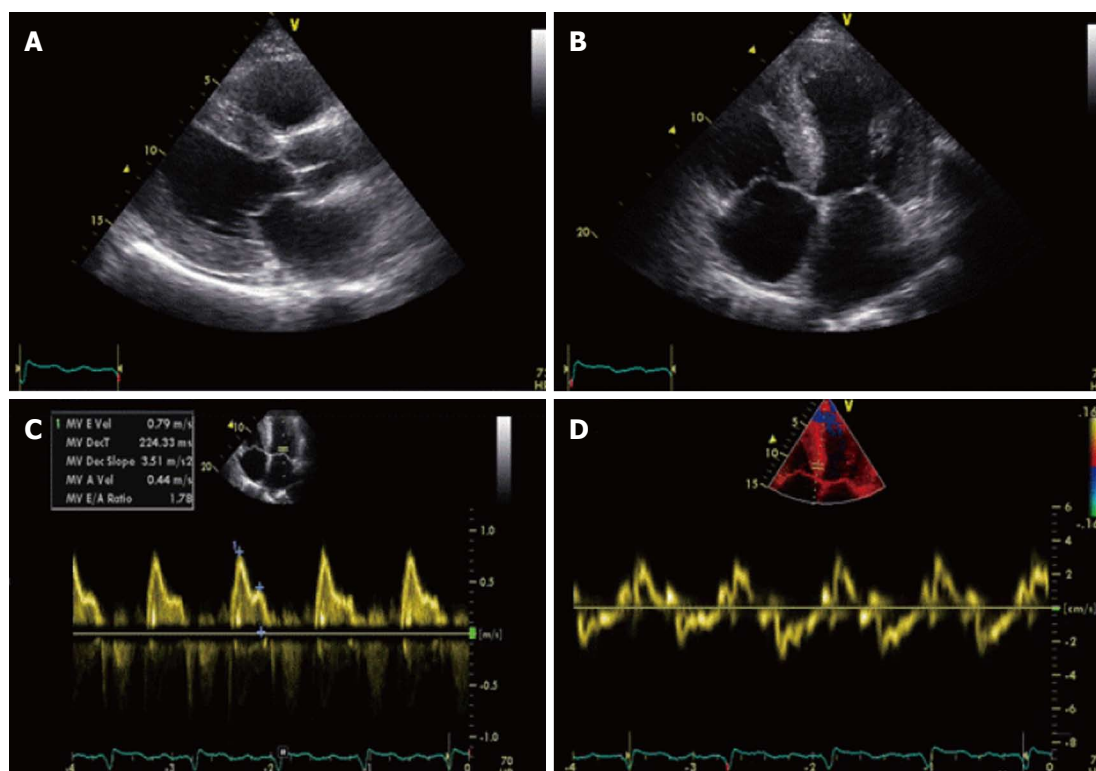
Transthoracic echocardiography images. A: Parasternal long axis view diastolic still frame demonstrating thickened myocardium with sparkling of the septum. IVSd 19 mm, LPWd 19 mm; B: Apical four chamber view end diastolic still frame demonstrating thickened myocardium and normal appearance of heart valves; C: PW Doppler measurement of MV inflow. MV E/A ratio 1.8; E-vel 0.80; A-vel 0.57; IVRT 77 ms; dt 224 ms; D: Tissue Doppler Imaging with PW Doppler measurement on medial annulus of MV with E' 3 cm/s E/E' ratio 26.2 confirming the diastolic dysfunction. S' 3.5 cm/s associated with impaired left ventricular function.
